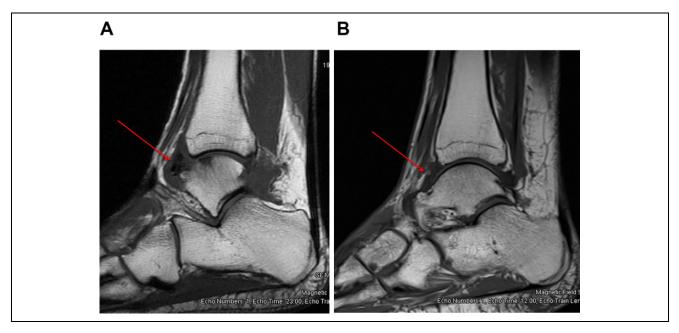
Magnetic resonance images demonstrating (A) fibrotic tissue at the anterior ankle joint line (red arrow) and (B) dense fibrotic tissue extending along the capsule of the joint (red arrow).
